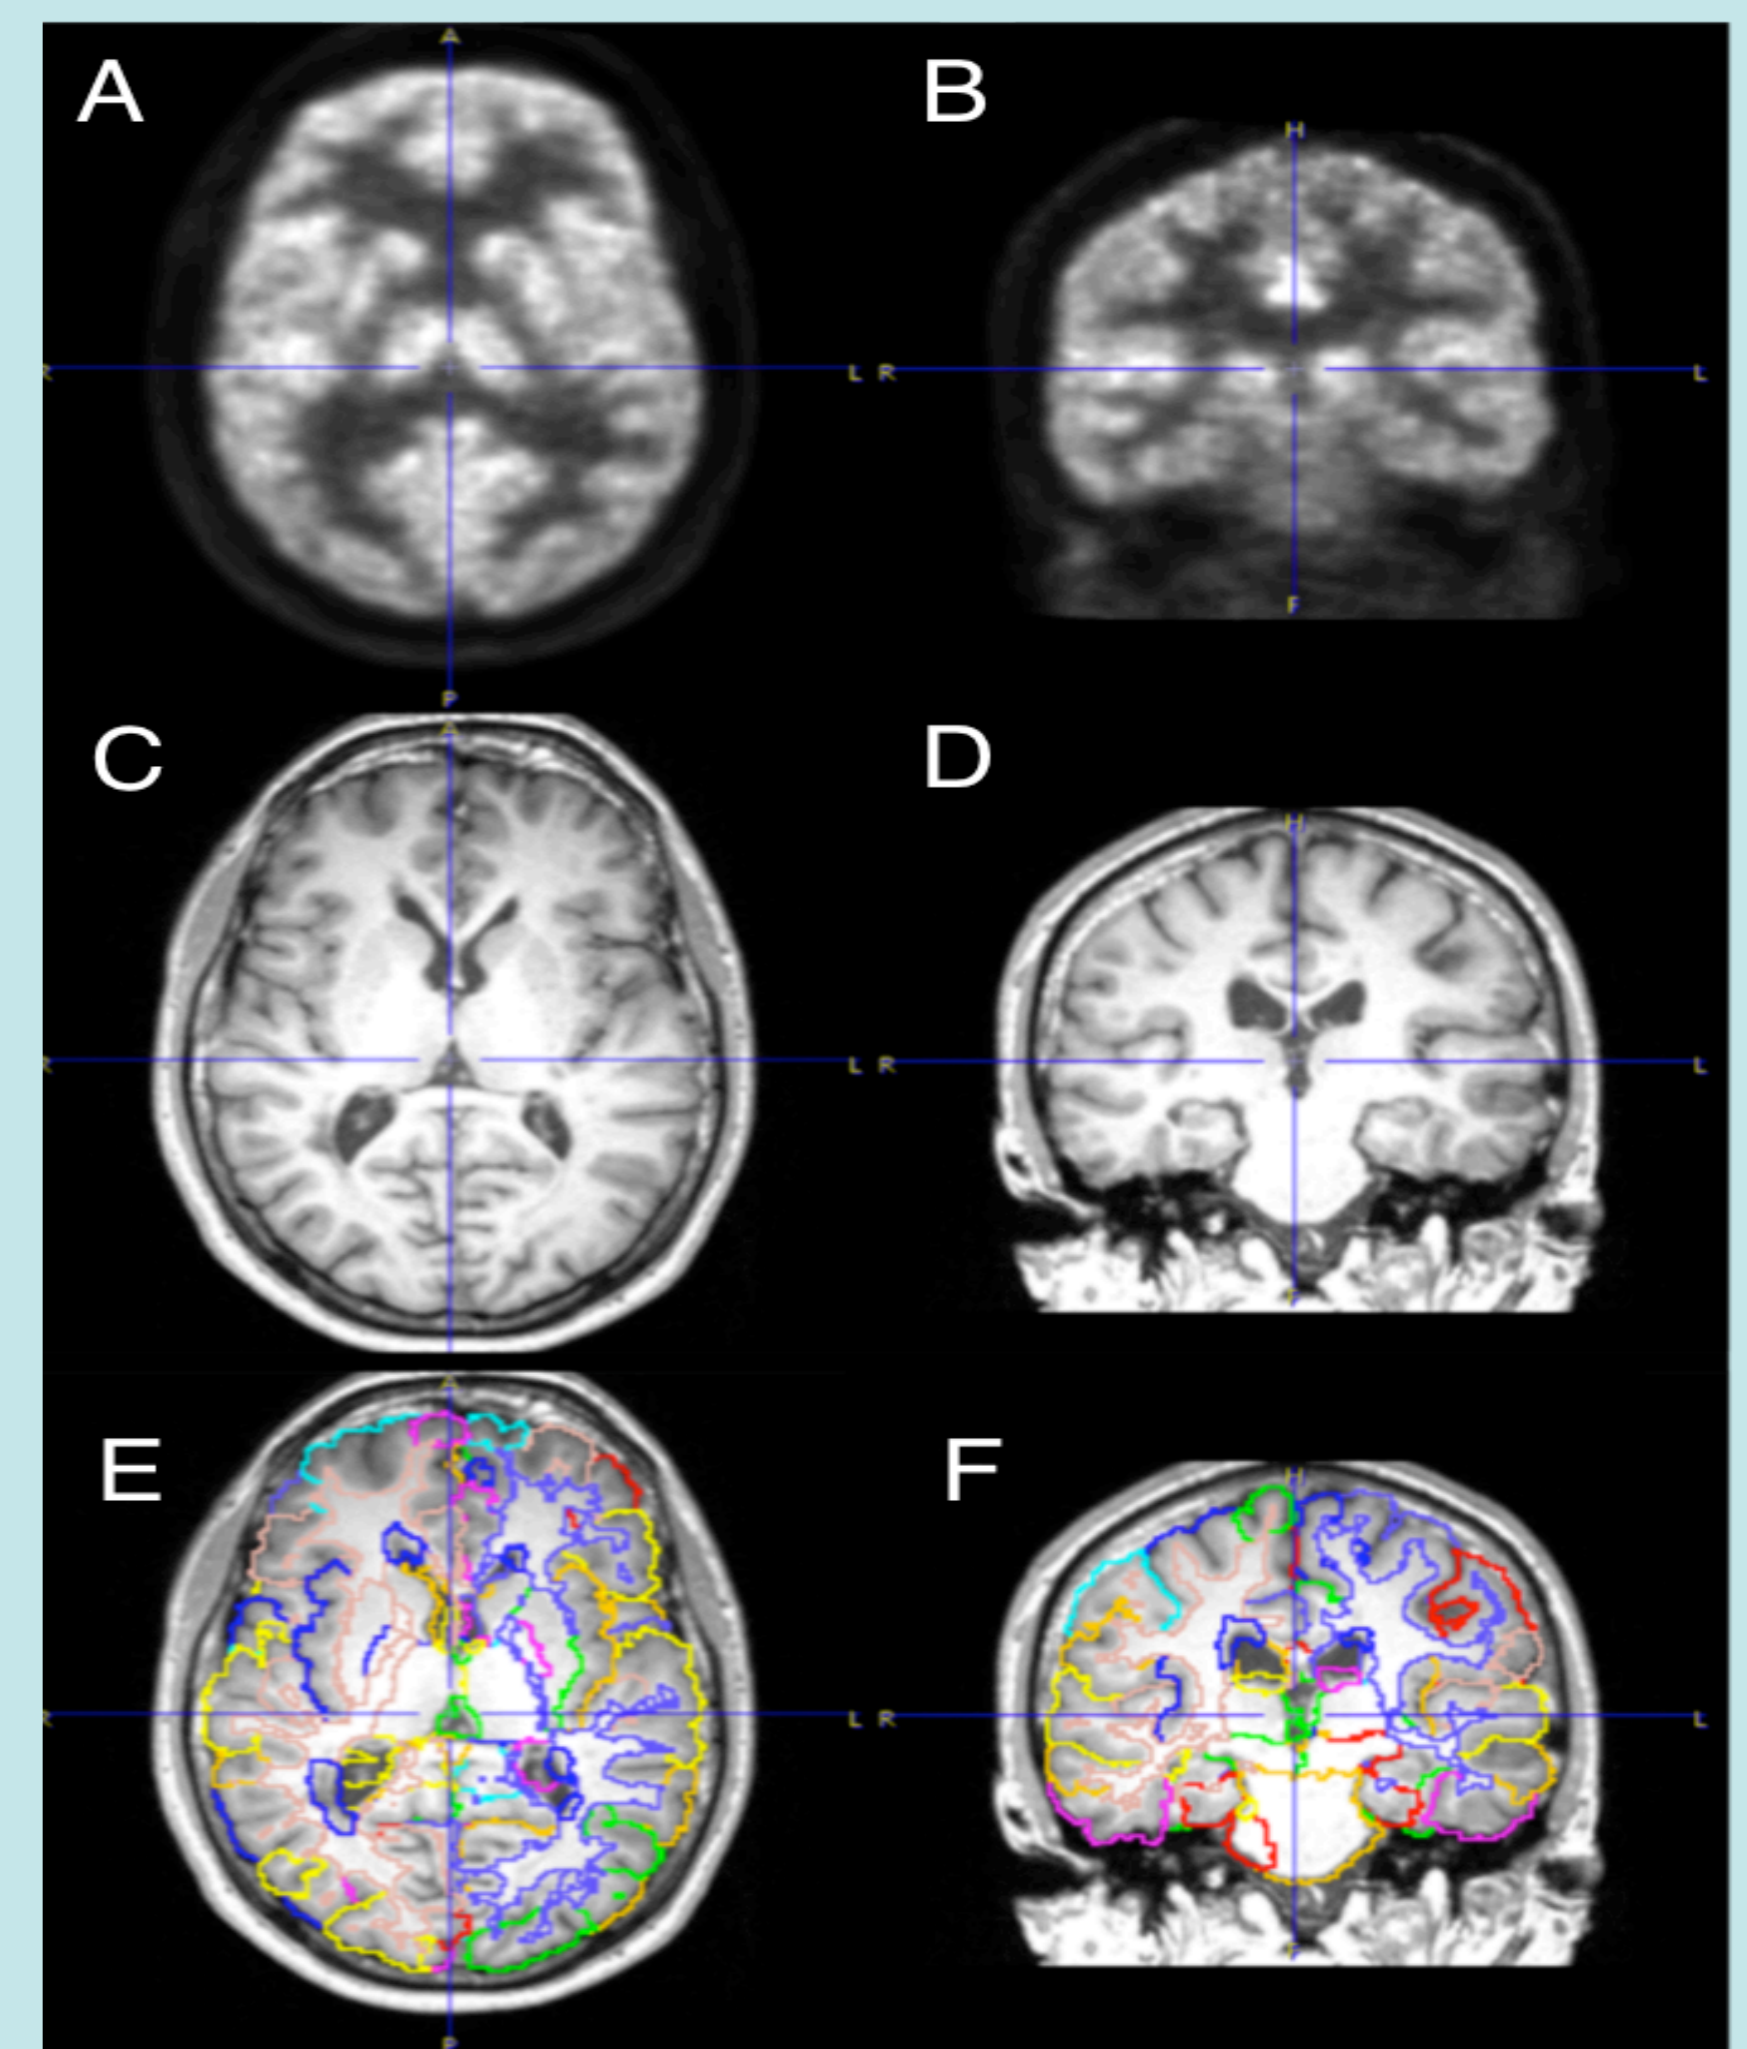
PET (A, B) and MRI (C, D) axial and coronal images acquired with fully integrated 3T PET/MRI system. Desikan Killiany atlas was applied on MRI dilated images overlapped on PET to analyse regional cortical thickness and metabolism (E, F).
